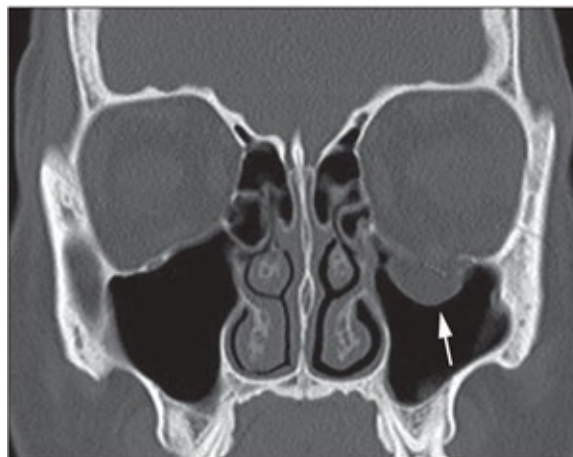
Coronal CT demonstrating orbital floor blowout fracture (arrow).
